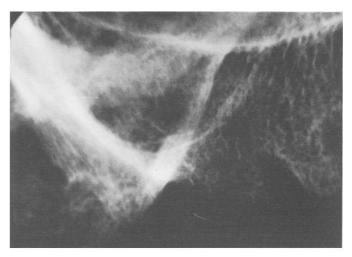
1991 postmortem radiographs.
